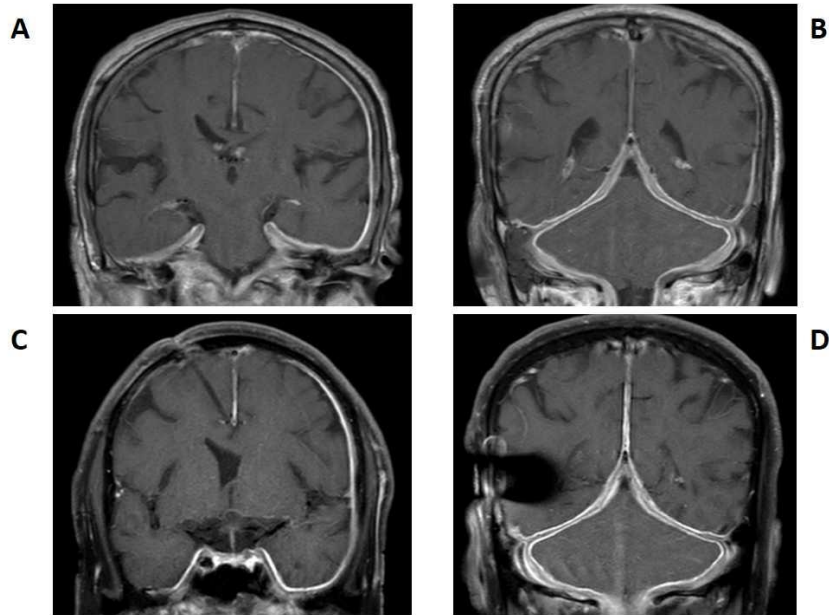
Brain magnetic resonance imaging (MRI) coronal view T1 sequence post-contrast showed linear dural thickening in the left hemisphere (A) and tentorium (B) before and after (C,D) steroid treatment.
